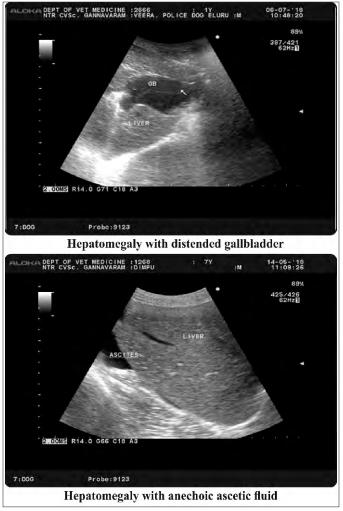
Abdominal Ultrasonographic findings
